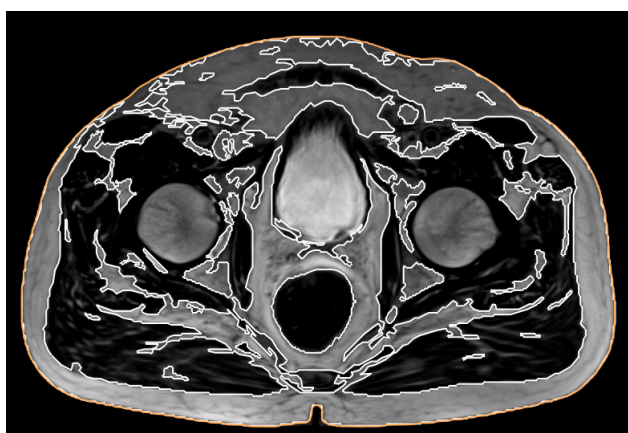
An MR image with delineations of areas defined as adipose tissue delineated in white. The orange line marks the external contour and sometimes overlaps the white line. One can see that the bladder and femurs are excluded from the delineation, although their grayscale value alone would be placed within the range for adipose tissue.
